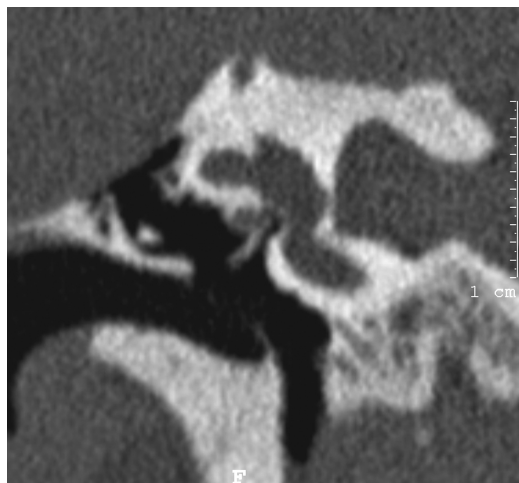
Coronal computed tomographic scan showing an example of dehiscent superior SCC, which overpasses the level of tegmen tympani (protruding canal).
